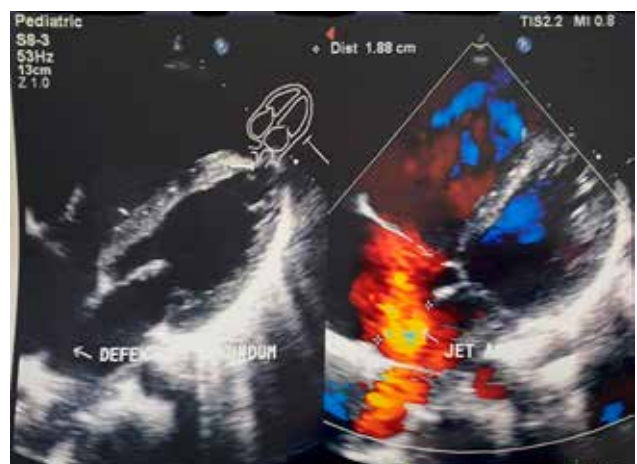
Echocardiography showing the ostium secundum ASD (Diameter 1.88 cm)
